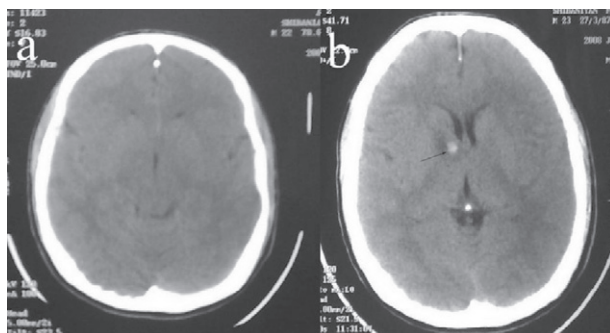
Unenhanced brain CT scan of the patient on admission [a] and on the following day [b]. Note the evolution of a small contusion at the periventricular region.
